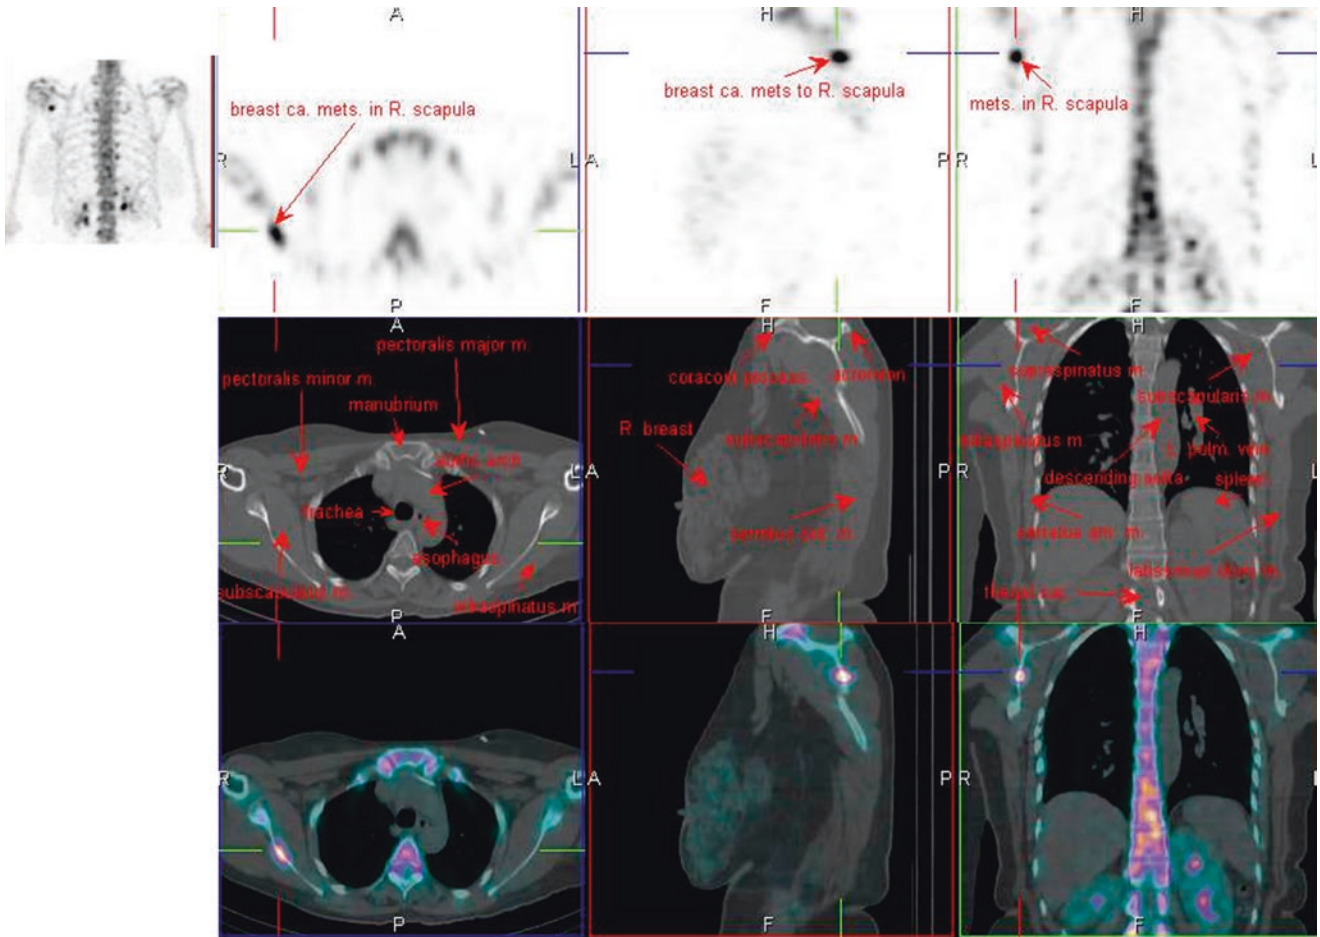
^{99m}Tc-MDP SPECT/CT
